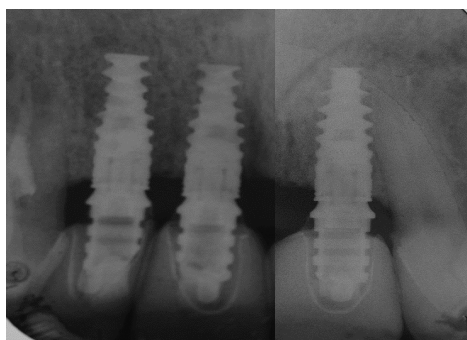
6-year follow-up intraoral radiographs.
